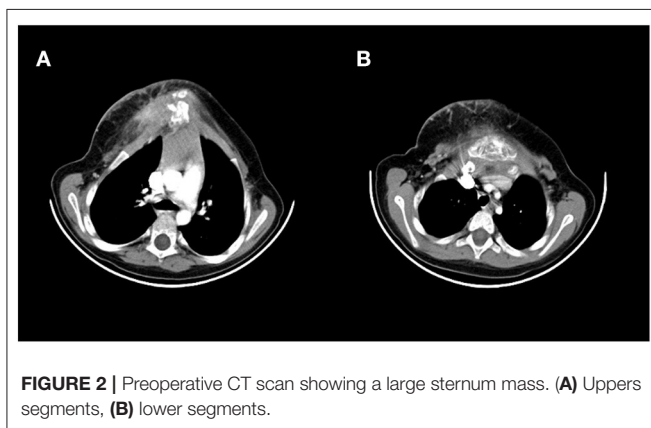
Preoperative CT scan showing a large sternum mass. (A) Upper segments, (B) lower segments.
